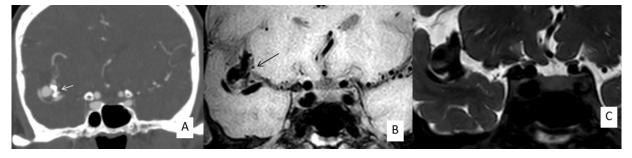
Case 12 patient with calcified aneurysm at right MCA (A) CT shows calcification at the wall of the aneurysm, (B, C) VWI show low signal of the calcification which may be missed as patent lumen.
